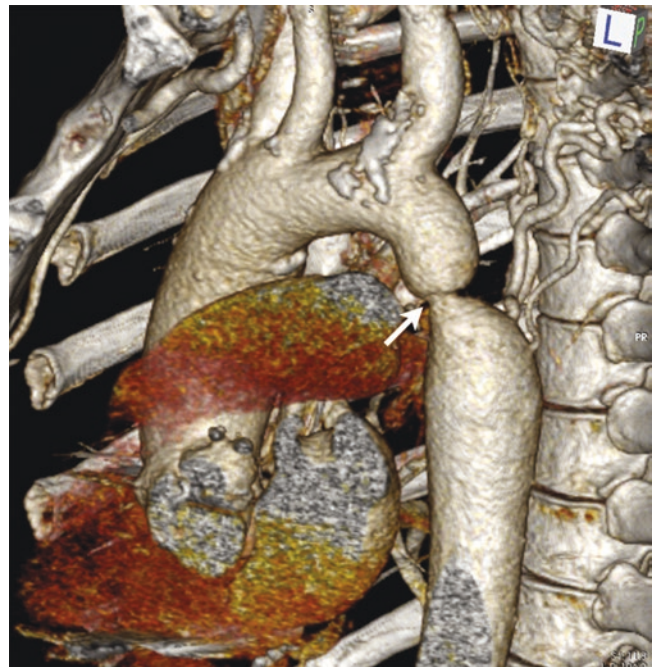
Coarctation of the aorta in a 17-year-old, first presentation, contrast-enhanced CT. 3D volume-rendered image, viewed from the left lateral aspect showing a tight native coarctation (arrow). Note multiple large collateral vessels around the site of the coarctation. CT imaging can define the optimal treatment option, stent diameter and length and risks associated with potential collateral damage
